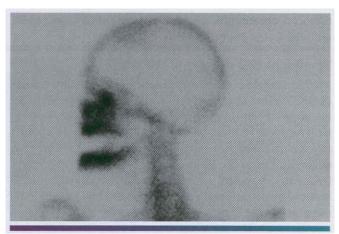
• Neuralgia-inducing cavitational osteonecrosis (NICO). Technetium 99m bone scan reveals multifocal and extensive NICO involvement (hot spots) years after extraction of the entire dentition for "atypical facial pain." None of the sites was visualized by routine radiographs. MRI, or CT scans, or other forms of radioisotope bone scans.
